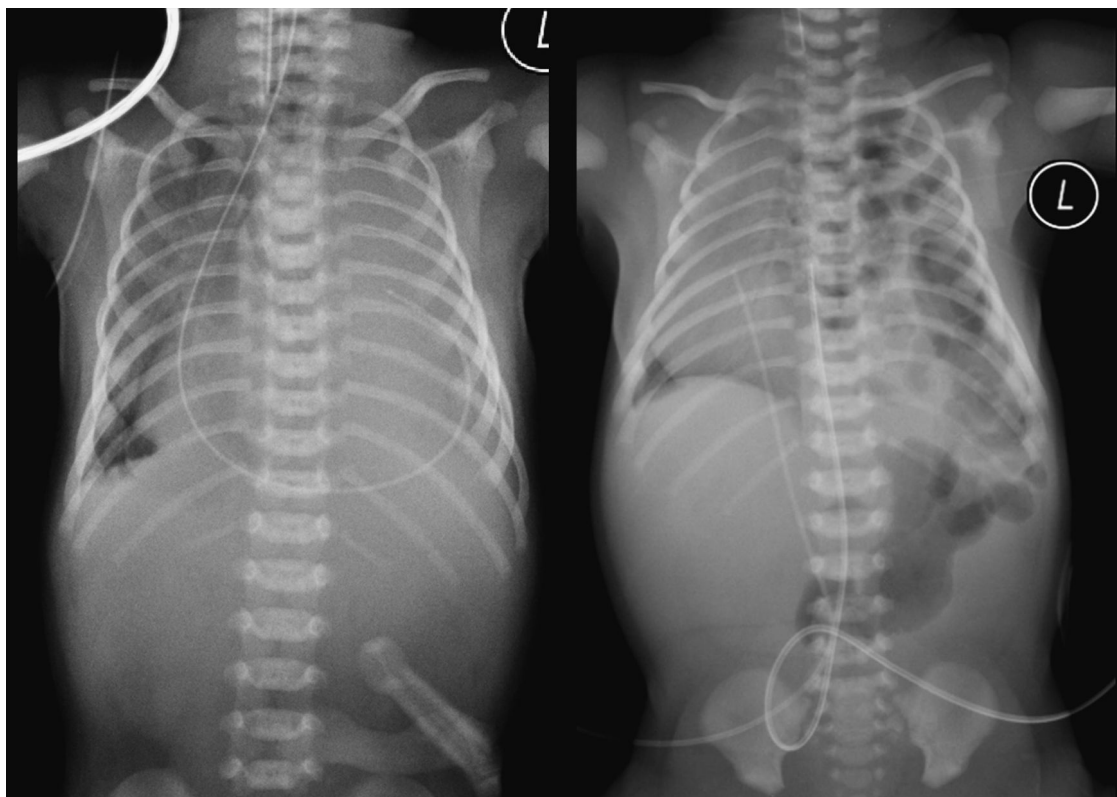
Two X-rays of infants with a congenital diaphragmatic hernia. The X-ray on the left demonstrates an infant with a left-sided diaphragmatic hernia who was intubated and paralysed from shortly after delivery. The ETT is at T1. The NGT can be seen in the intrathoracic stomach, and there is no gas in the gut. Contrast with the infant on the right, who has no gastric tube *in situ*, and a large amount of gas in the gut.
